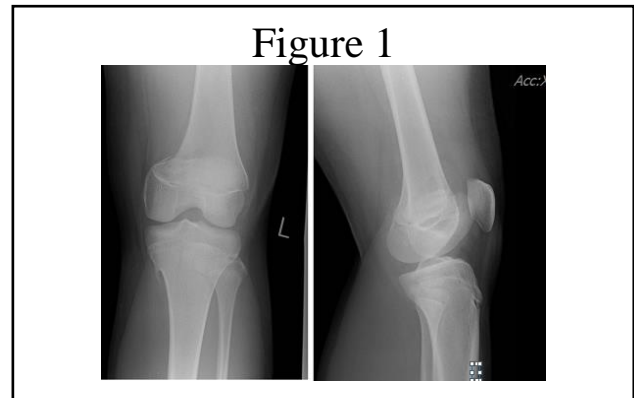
Post trauma Xray
